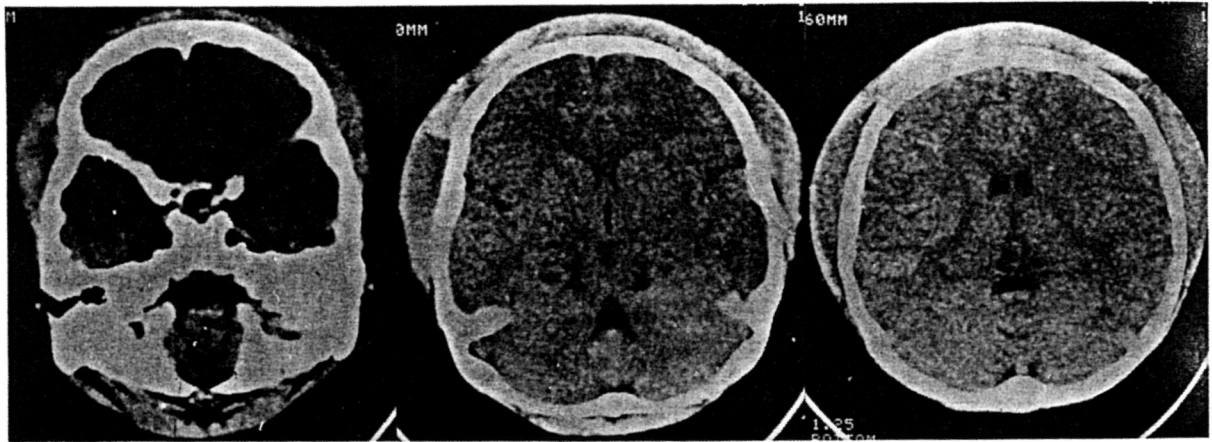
CT scans of the brain reveal extensive soft tissue swelling in both frontotemporo-parietal region.
